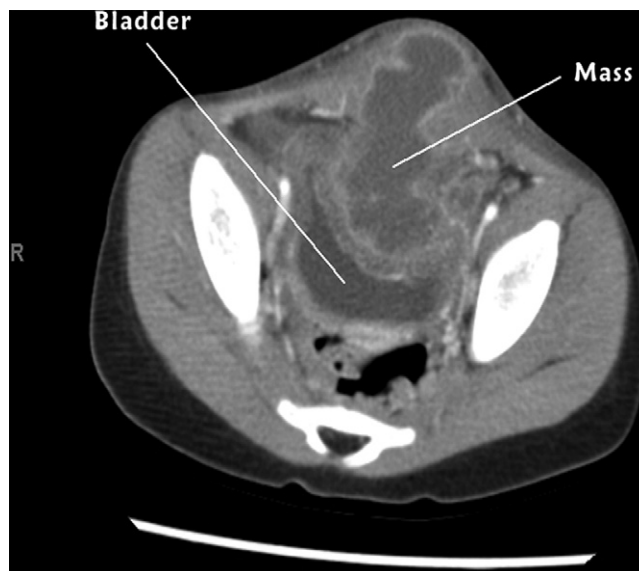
Representative axial CT section. Used with permission of Derek R Linklater, MD, Department of Pediatrics, Section of Emergency Medicine, Baylor College of Medicine/Texas Children's Hospital, Houston, TX.
